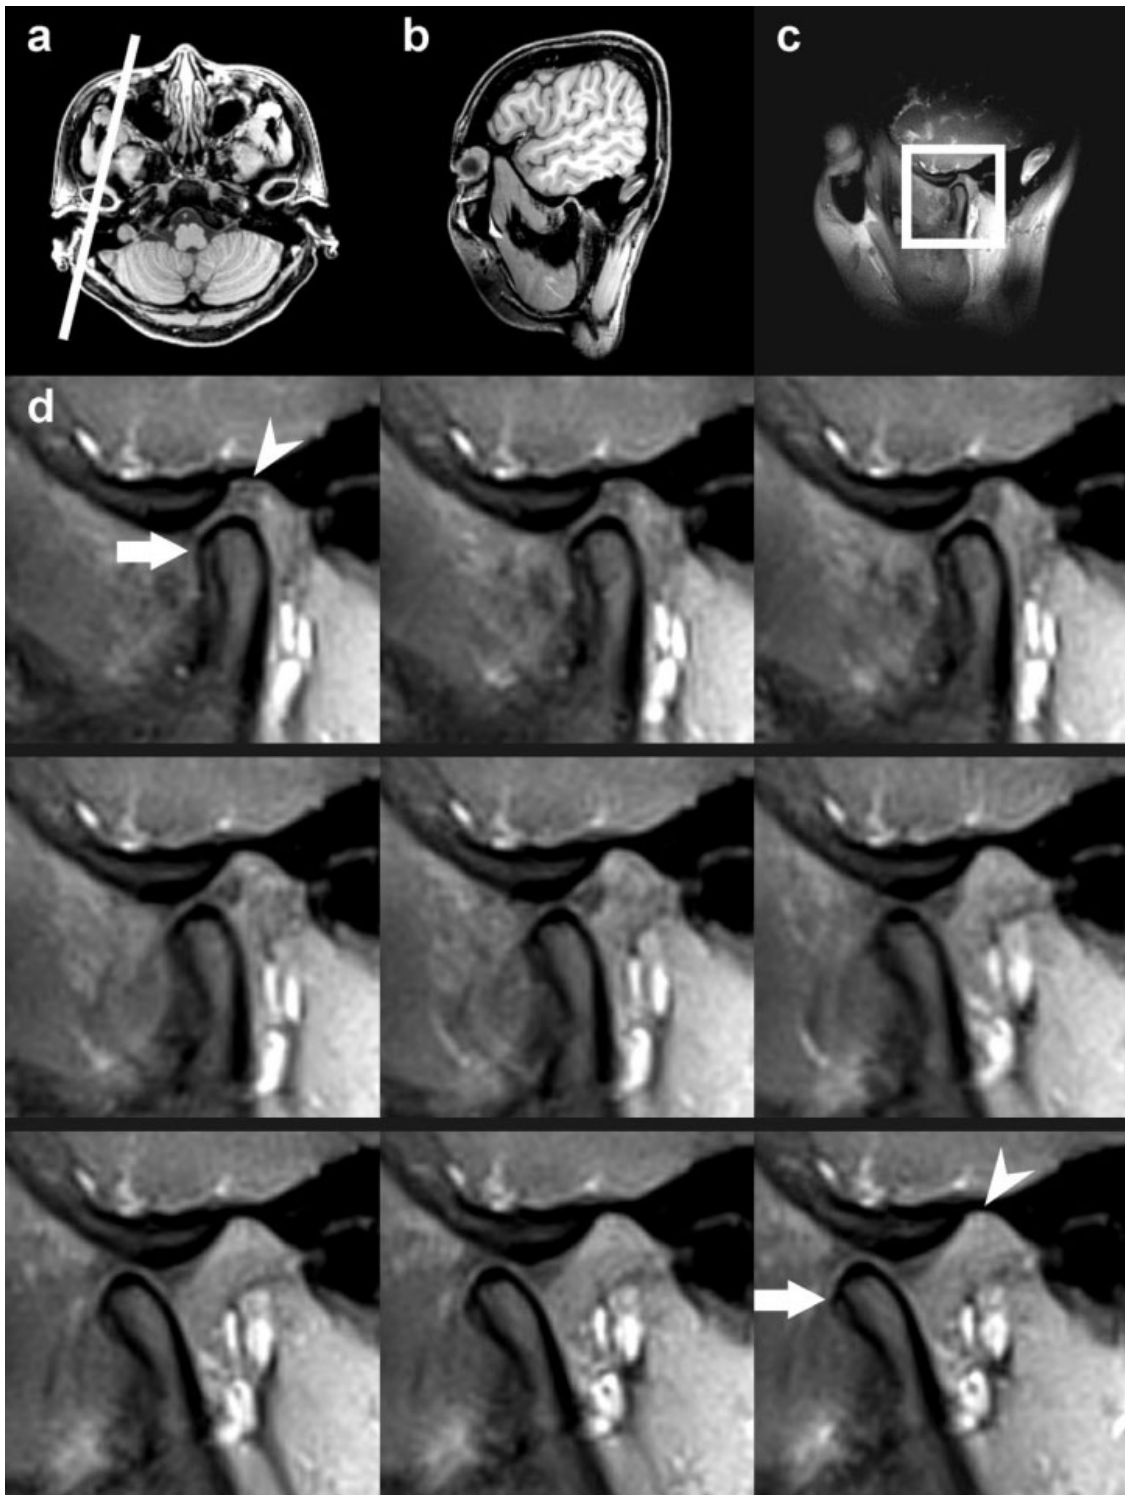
Real-time MRI of the temporomandibular joint during voluntary opening of the mouth at 3 Hz frame rate. a: Transverse and (b) oblique sagittal view of a healthy subject demonstrating the section for the right joint. c: Corresponding re-focused radial FLASH image at 0.75 mm in-plane resolution and 5 mm section thickness (TR/TE = 4.33/2.10 msec, flip angle 20°, 192 mm FOV, base resolution 256, 385 spokes, image update every 75 spokes, no channel compression). d: Magnified views selected every 5 seconds demonstrate the anterior displacement of the condyle relative to the articular fossa (arrows).
